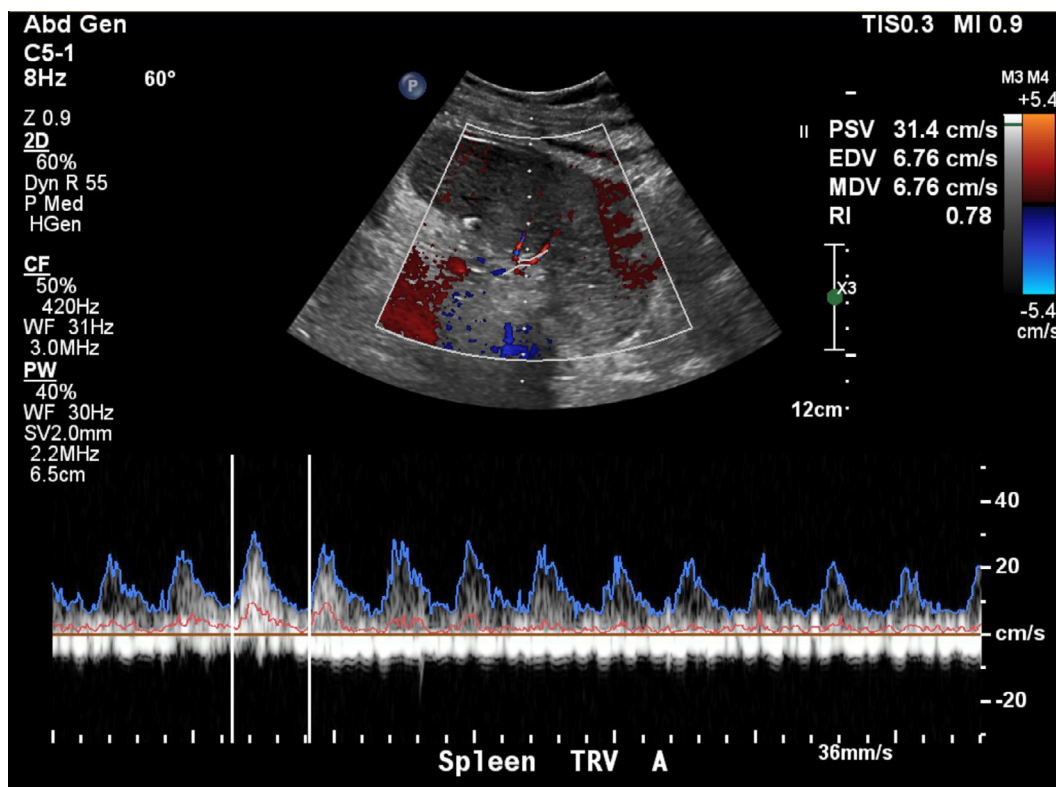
Ultrasound of the spleen demonstrates heterogeneous internal echotexture with preserved parenchymal Doppler flow and splenic artery spectral arterial waveforms.
